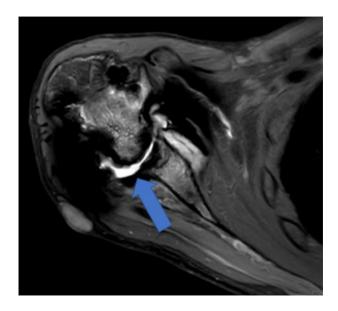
MRI right shoulder axial section T2 sequence shows joint effusion (blue arrow).
